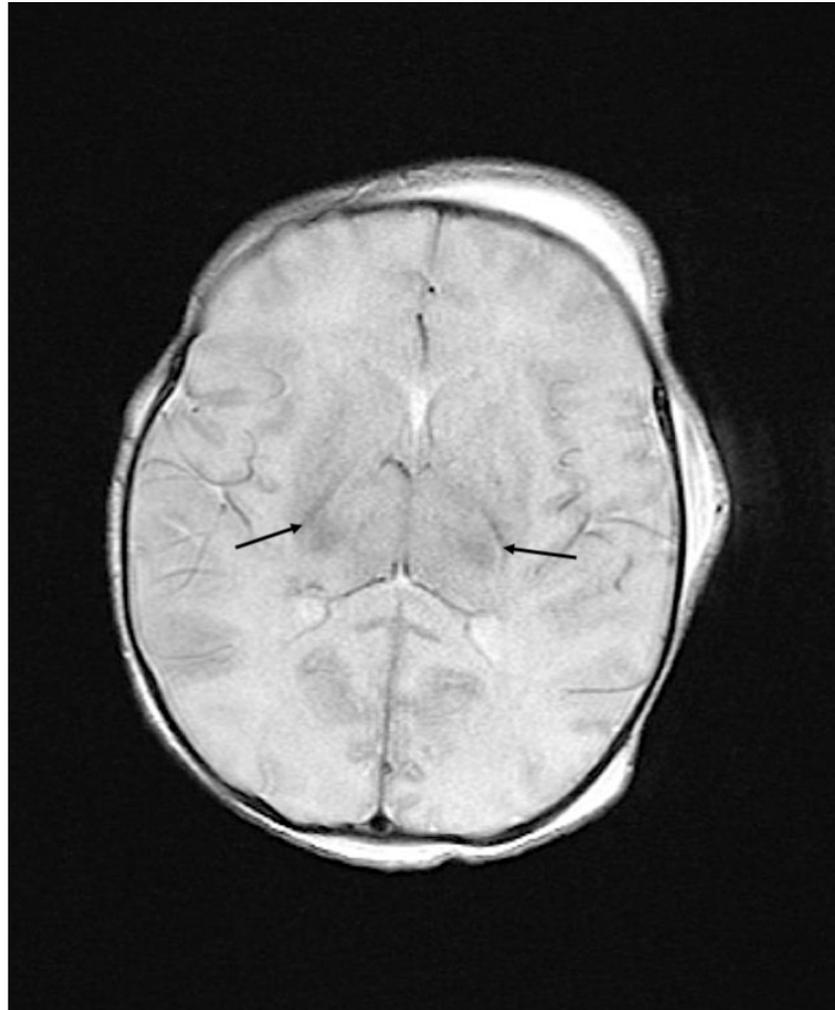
MRI study (T2 relaxation weighted image) of an infant showing abnormal signal within the posterior limb of the internal capsule (black arrows)
